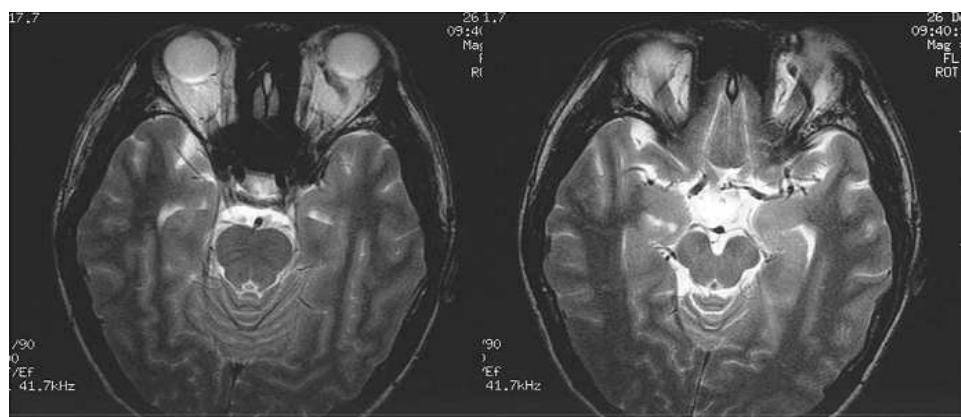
Axial T2-weighted magnetic resonance image showed the left dilated ophthalmic vein.
